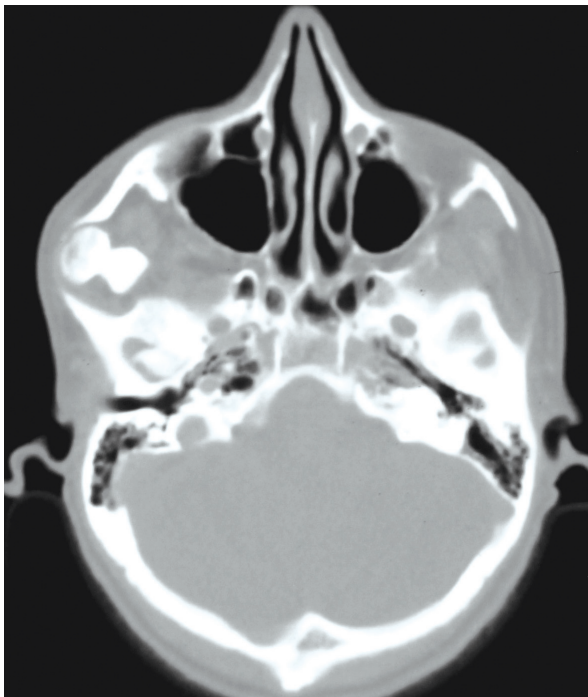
Axial CT image at the level of the zygomatic arch shows a mushroom-shaped osteochondroma of right coronoid process and the extent of the mass into inner surface of the zygomatic arch.
